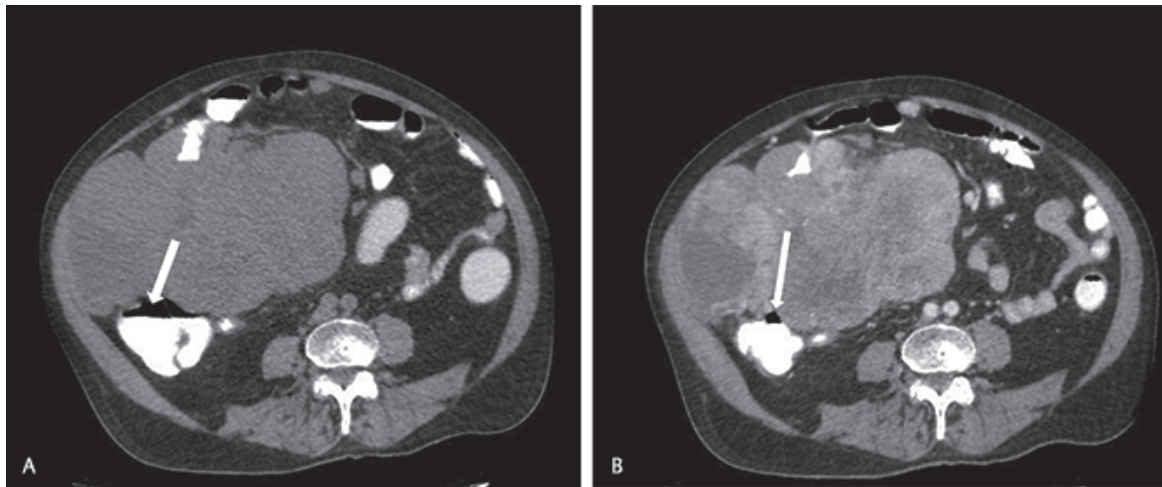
(A) Plain and (B) contrast-enhanced CT axial images show large exophytic moderately enhancing jejunal gastrointestinal stromal tumor (GIST) with central necrosis and lobulated and irregular contour. There was invasion of adjacent ascending colon (white arrow) High risk. Mitotic index (MI): $> 5 / 50$ HPF. Size: 21 cm.
